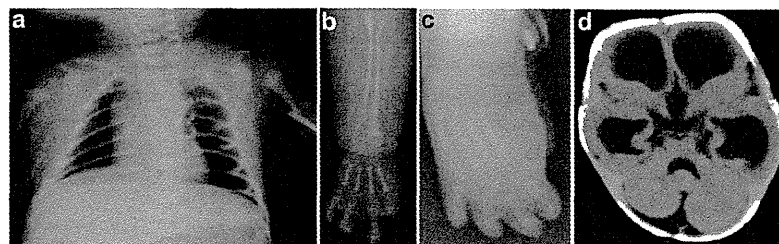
Imaging studies of the proband. (a) Thoracoabdominal X-ray on the first day after birth (dorsal position). Hypoplasia of both clavicle and the fracture of left humerus were evident. (b) X-ray of left forearm and hand. Absence of thumbs and hypoplastic phalangeal bones were observed. (c) X-ray of right foot. Absence of halluces and hypoplastic phalangeal bones was noted. (d) Head CT. Extended hypoplasia of the cerebrum and enlargement of the third and the lateral ventricles were noted. The fourth ventricle was also slightly enlarged.
